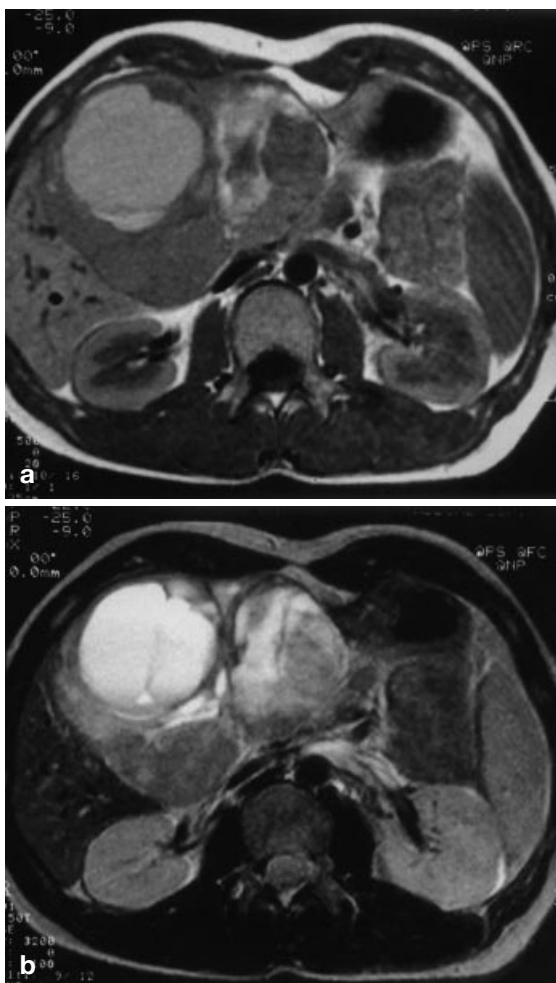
Subacute intratumoral bleeding, associated with extracellular metahemoglobin, gives a markedly high signal intensity both on a T1- and b T2-weighted MR images
